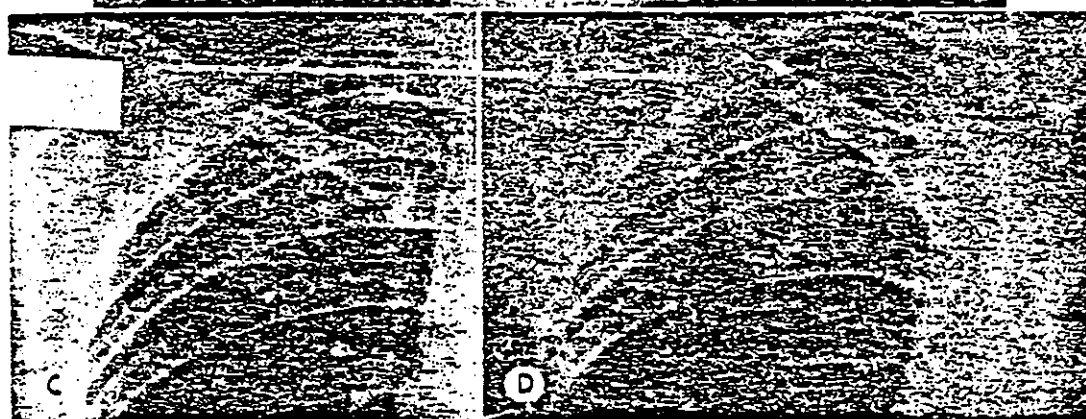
(B) Roentgenogram made in 1951, four years later. There are conglomerate masses in each upper lobe. (C) March, 1954. A small cavity is developing in the lower portion of the conglomerate mass (arrow). (D) April, 1955. The cavity is larger. No tubercle bacilli have been demonstrated. A presumptive diagnosis of anemic infarct has been made, but frequent examinations for tubercle bacilli are continuing.
